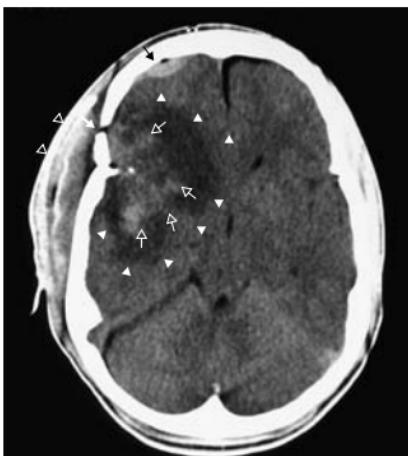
Direct impact (non-enhanced CT). Blunt trauma to the right frontal region with extracranial soft tissue swelling (open white arrowheads) and right frontal fracture (closed white arrow). There is an extensive underlying parenchymal contusion comprising low attenuation components (closed white arrowheads) and central haemorrhagic change (open white arrows). There is associated mass effect with ipsilateral sulcal and ventricular effacement and minor distortion of the midline. Note also the small right frontal extradural haematoma (black arrow).
